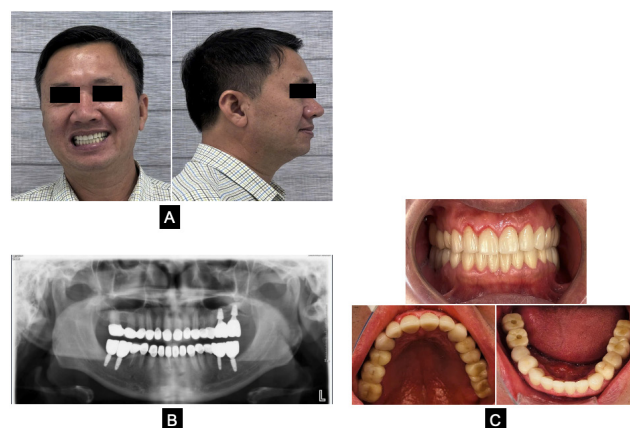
Case 2. After treatment (male patient), frontal and lateral views of the face (A), panoramic radiograph (B), and intraoral frontal view, upper arch and lower arch (C).
